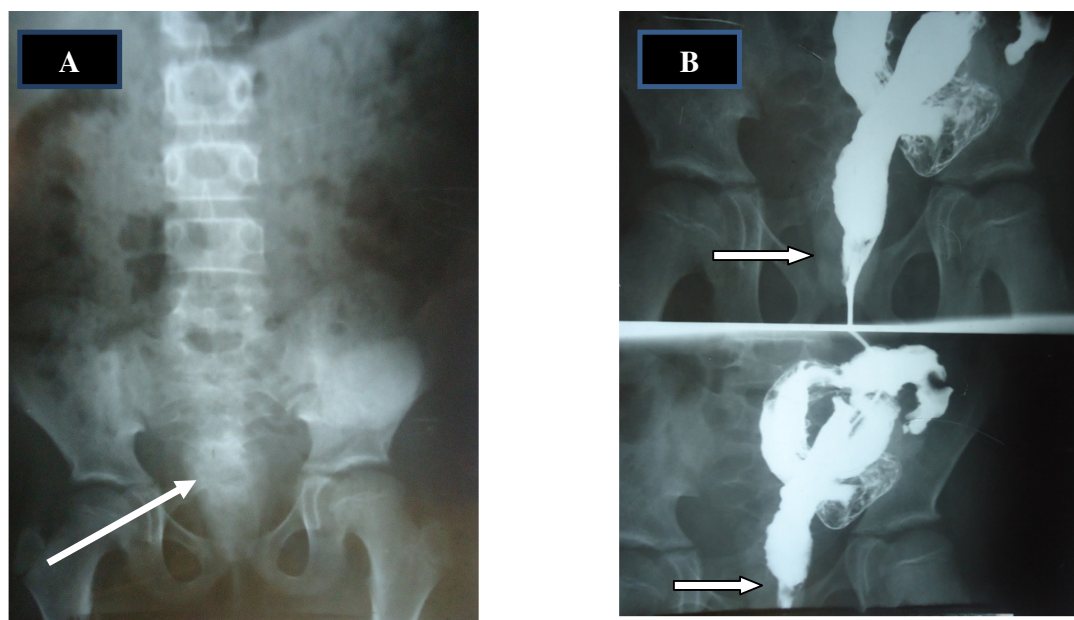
Plain abdominal x-ray(A) and distal colostogram(B) showing radio-opaque shadow in the pelvis(arrow)
